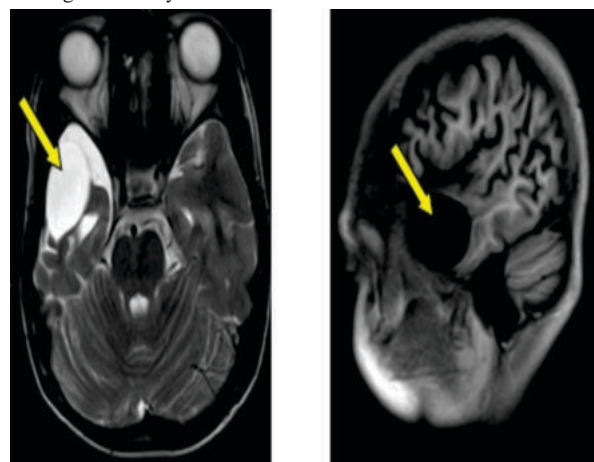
14 years old patients with 2 episodes of seizures. MRI shows well-defined extra axial fluid signal intensity lesion m/s 3.6x2.3cm in the right temporal region causing mass effect over adjacent temporal lobe - arachnoid cyst.
